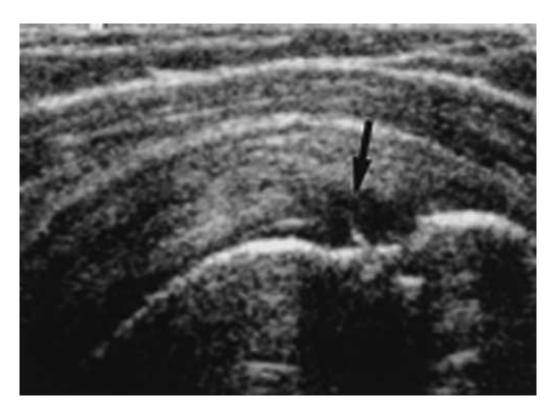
Partial thickness rotator cuff tear on Diagnostic Ultrasound (From Matava et al. (2005). Partial-thickness rotator cuff tears. *American Journal of Sports Medicine*, 33, 1405-1417).
